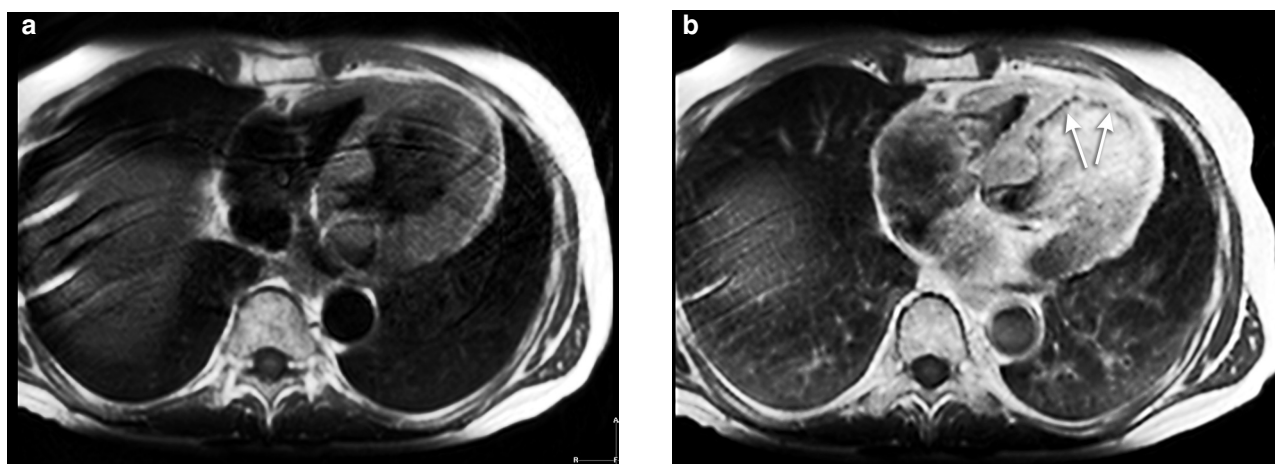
T1-weighted images before (a) and after (b) intravenous administration of paramagnetic contrast (Gadodiamide, 0.2 mmol/kg). The arrows indicate the thin dark line at the endocardial border that represents the obstructed microcirculation zone.
